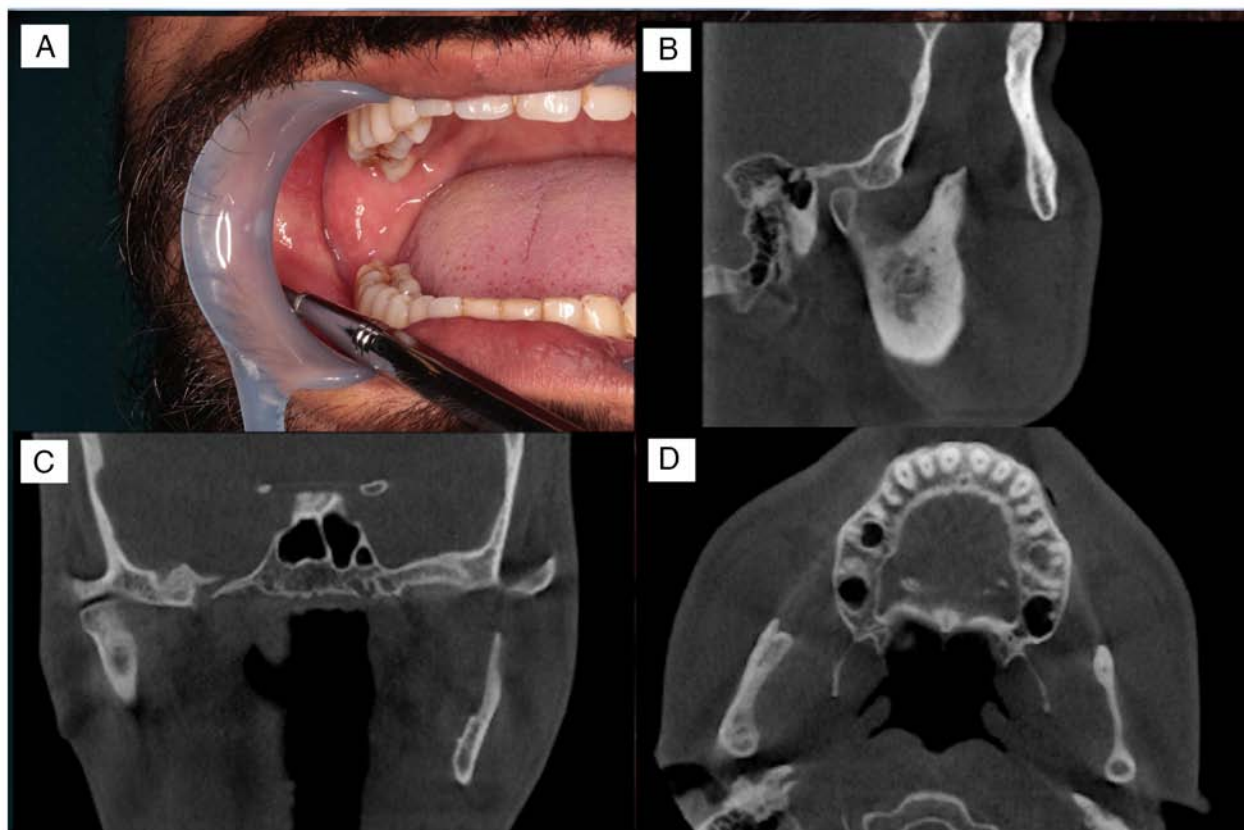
Postoperative findings. (A) Intraoral view of the mandible. (B) Sagittal, (C) coronal and (D) horizontal views of postoperative cone-beam computed tomography image findings. There were no signs of local recurrence.
